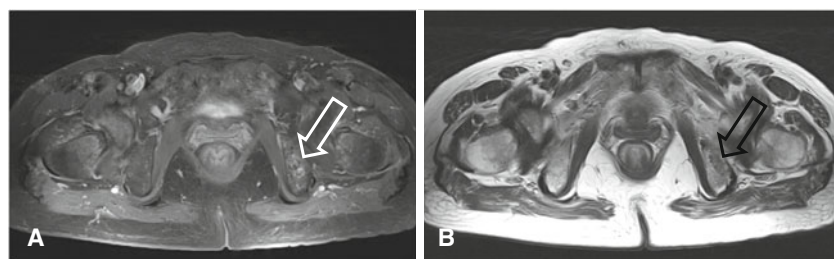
a, b Pelvic MRI findings. a Axial gadolinium-enhanced T1-weighted fat-suppressed MR image, b axial T2-weighted MR image. A 2.1-cm ovoid lesion was identified on the left ischium. T1-weighted
